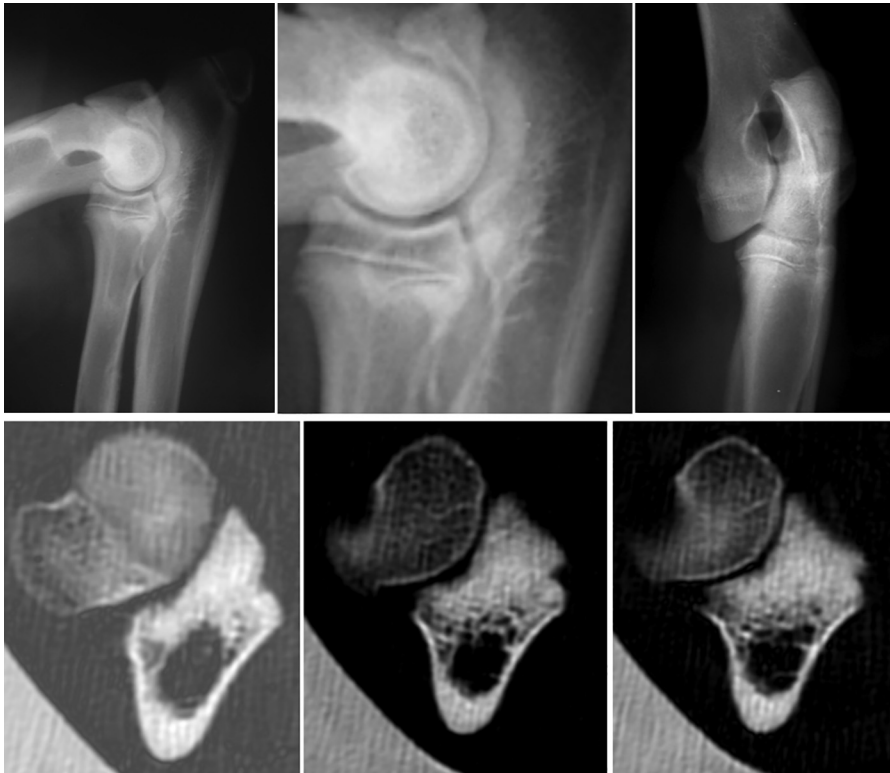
A computed tomography scan provides a diagnosis of certainty in cases of doubtful radiographic diagnosis like in this Saint Bernard, female, 8 months, with doubtful STS in the radiograph, whereas the computed tomography scan shows the irregular shape and density of the MCP. (Courtesy Federica Rossi.)
